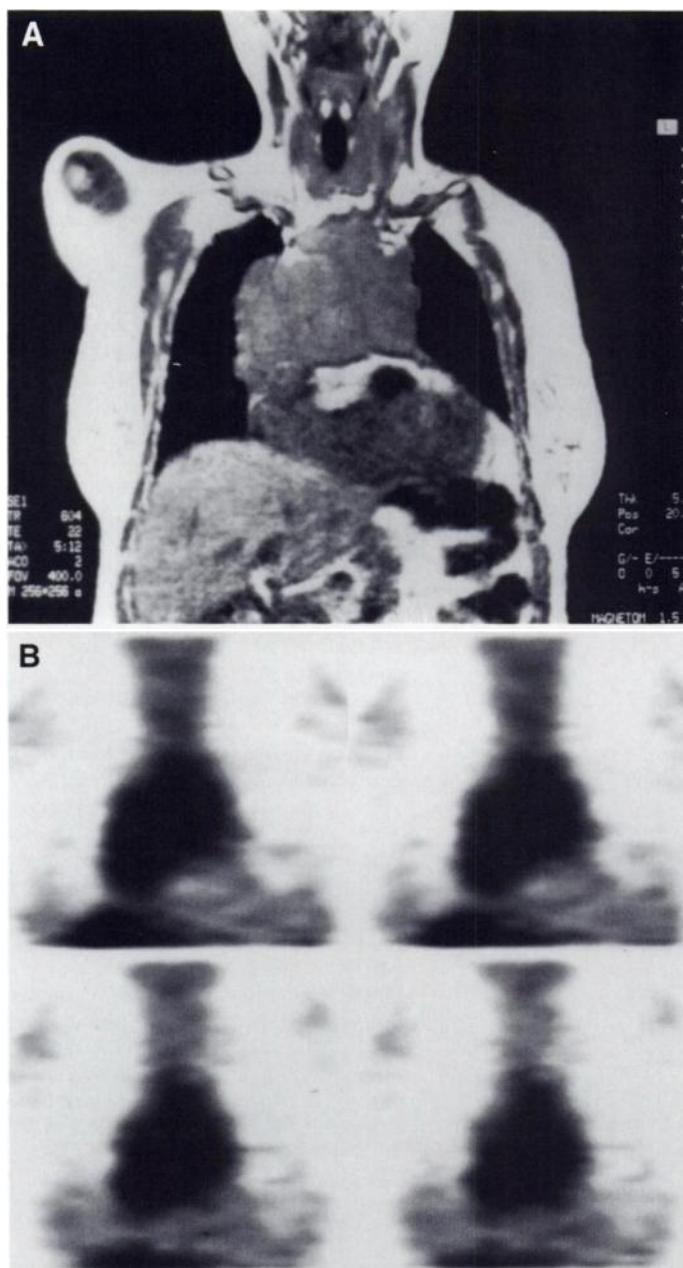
MRI T1-weighted images of Patient 2. (A) Coronal image clearly delineates tumor extent and anatomical boundaries. The structure is characterized by several lobules well-defined by fibrous septa. This finding is commonly described in aggressive thymomas. (B) SPECT with [¹¹¹In-DTPA-D-Phe¹]-octreotide: coronal views show intense tracer accumulation in the thymoma.
